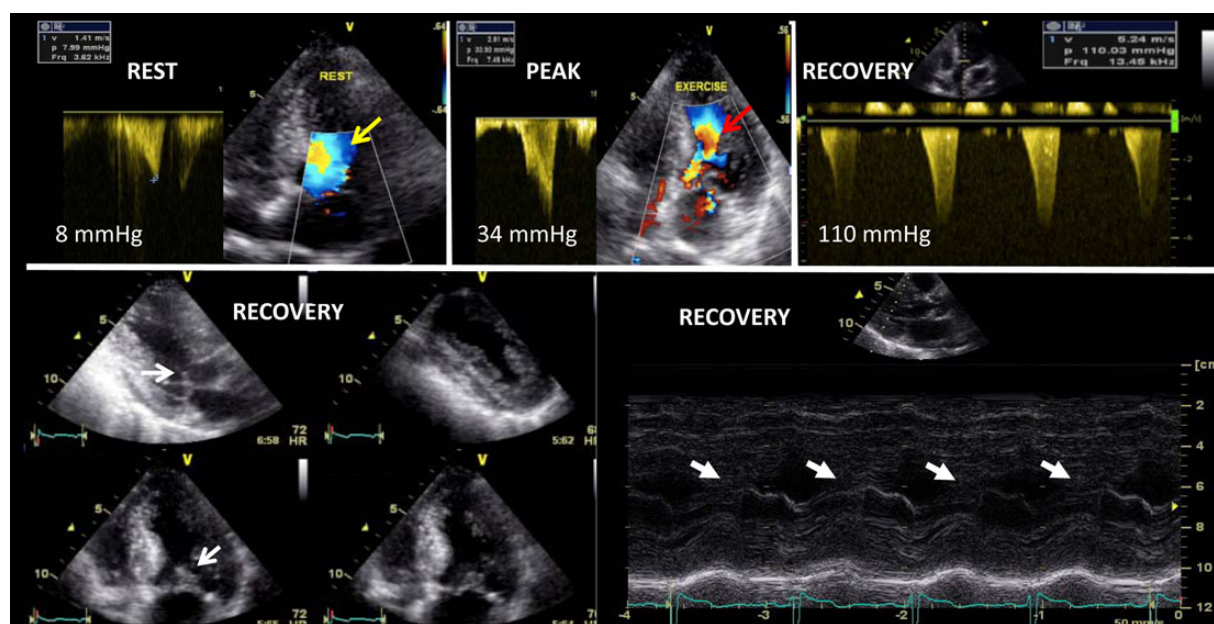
Example of dynamic intraventricular obstruction during exercise echocardiography in a dyspneic patient with HCM. *Top*: Increase in left ventricular outflow tract velocity and gradient associated with a marked flow acceleration (red arrow) (note the laminar flow at rest (yellow arrow)). Note the greater increase in intraventricular gradient after exercise due to the decrease in venous return. *Bottom*: Systolic anterior motion of the mitral valve identified on 2D (left) and M-mode (right) echocardiography (white arrows).
